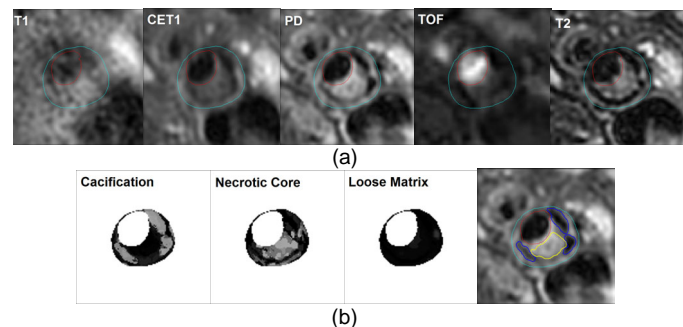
(a) MR images (b) probability map and final segmentation (1 necrotic core and 3 calcifications are displayed in a PD image)
